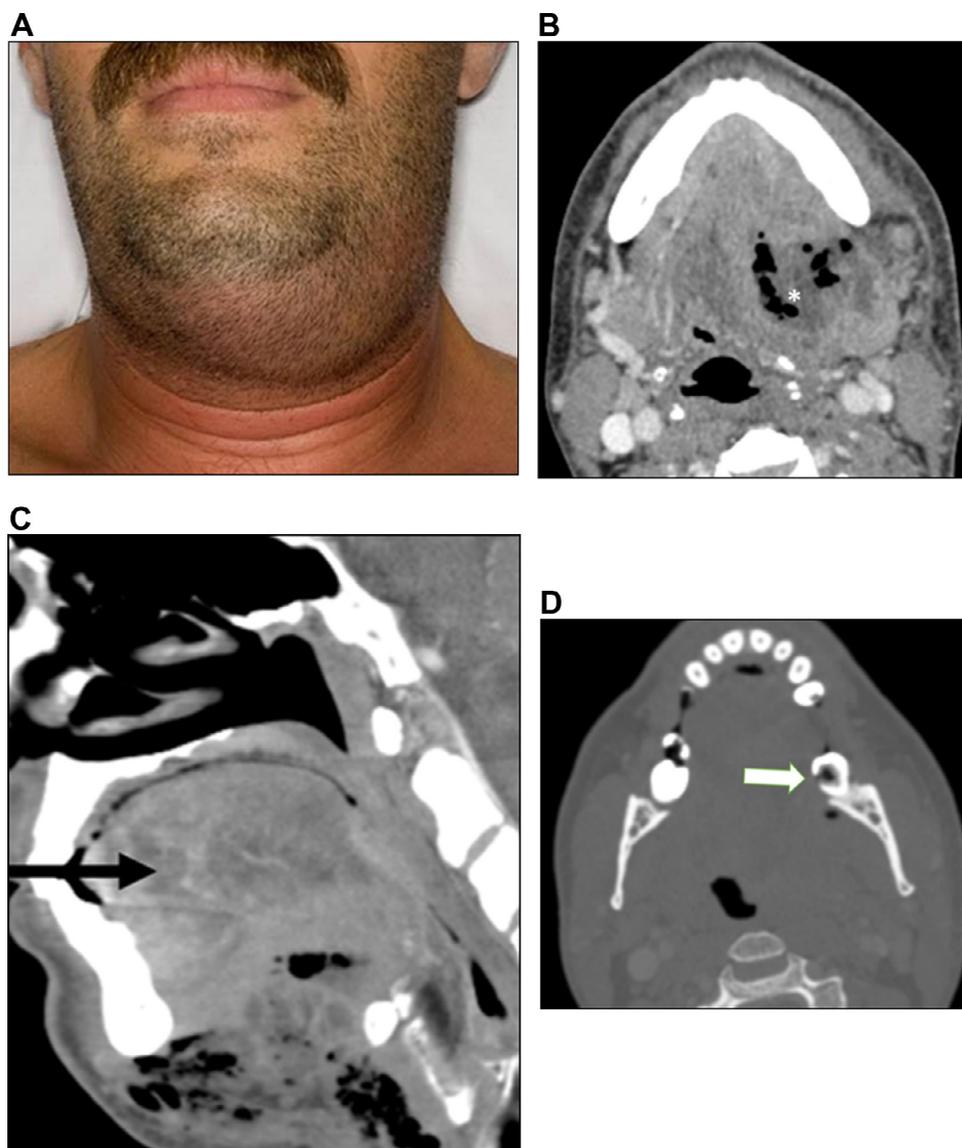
A-D: Ludwig's angina. Forty-year-old male presenting with worsening facial swelling and redness (A). Axial contrast enhanced CT neck (B) reveals extensive sublingual and submandibular space edema with air indicating abscess formation (*). Sagittal reconstruction (C) reveals elevation of tongue (black arrow). Bone window (D) evaluation of the teeth reveals poor dentition (white arrow), likely the cause of this patient's Ludwig's Angina (Courtesy Jonathan Morris, MD). (Color version of figure is available online.)
